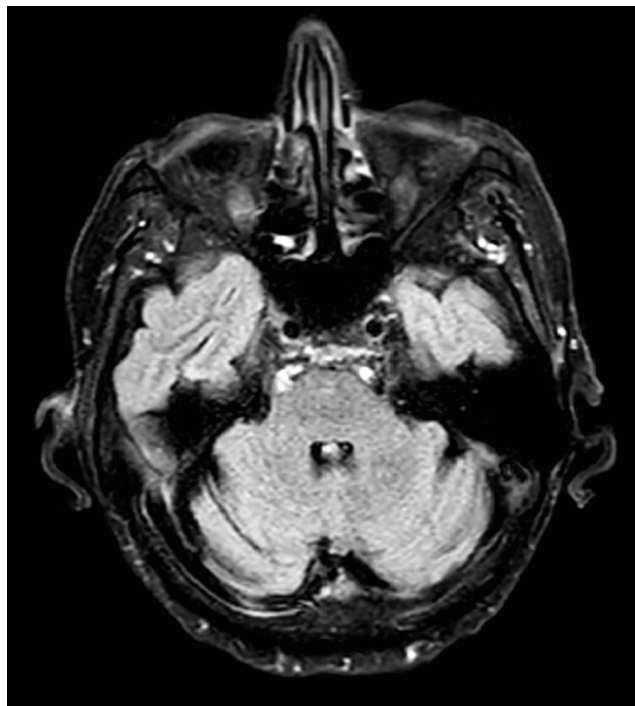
A follow-up brain magnetic resonance image showed the resolution of the hyperintensity in middle cerebellar peduncles (in T₂-FLAIR sequences).
